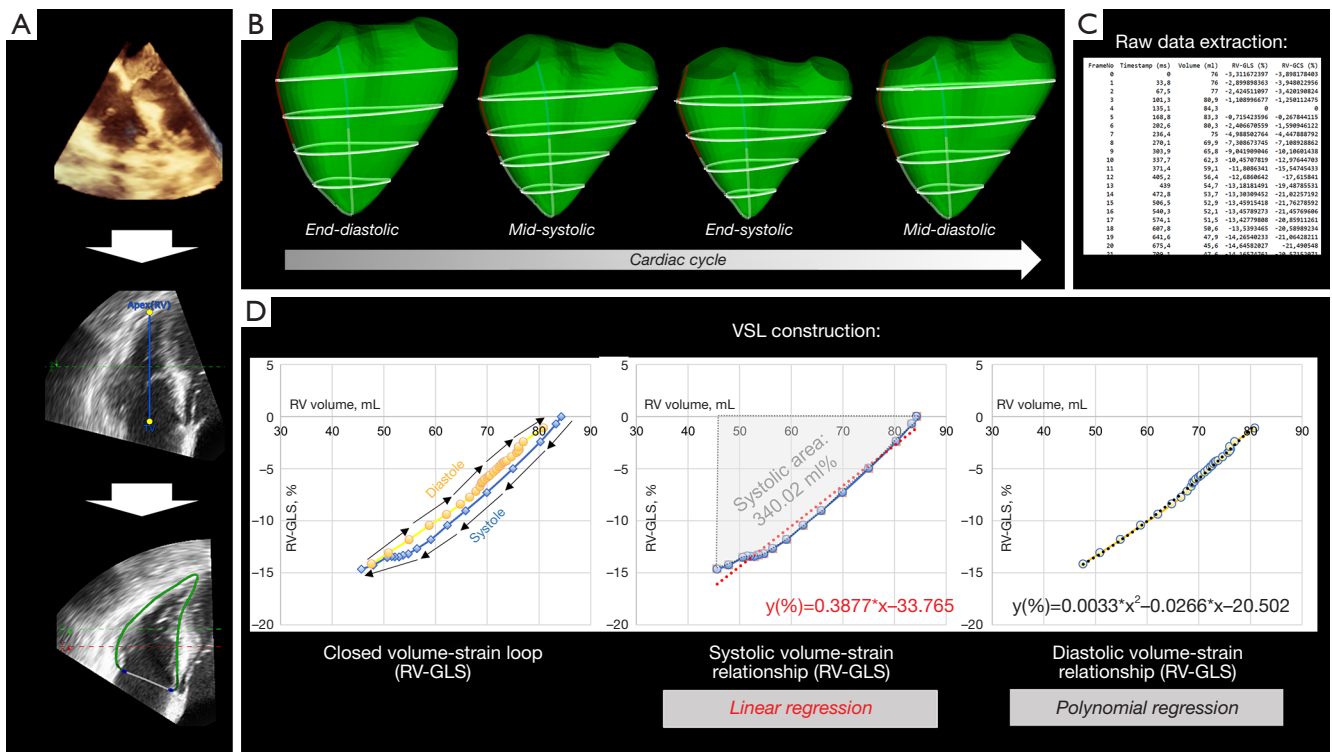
Generation of RV VSLs using simultaneously recorded volume and strain data from 3D speckle-tracking echocardiography-derived mesh models. (A) Offline segmentation and semi-automatic endocardial border detection of 3D echocardiographic RV studies using speckle-tracking. (B) The generated mesh models undergo volume and strain analysis (right ventricular global circumferential strain “RV-GCS” and right ventricular global longitudinal strain “RV-GLS”) of the whole cardiac cycle employing a custom-made software. (C) Volumetric and strain data are generated frame-by-frame and exported into a raw data file. (D) VSLs are constructed for the whole cardiac cycle (closed VSL) as well as for the systolic and diastolic phases separately. Exemplary display of a linear regression model of the systolic volume-strain relationship (red dotted line) and a polynomial regression model of the diastolic volume-strain relationship (black dotted line), respectively. RV, right ventricular; VSLs, volume-strain loops; RV-GCS, right ventricular global circumferential strain; RV-GLS, right ventricular global longitudinal strain.
